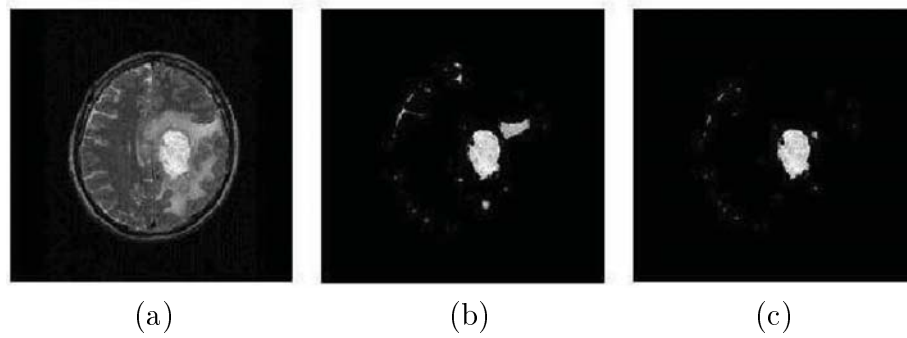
Patient dataset-1: (a) original un-segmented brain MRI, (b) optimized MRI image using HPSOWM, (c) segmentation using the proposed method
